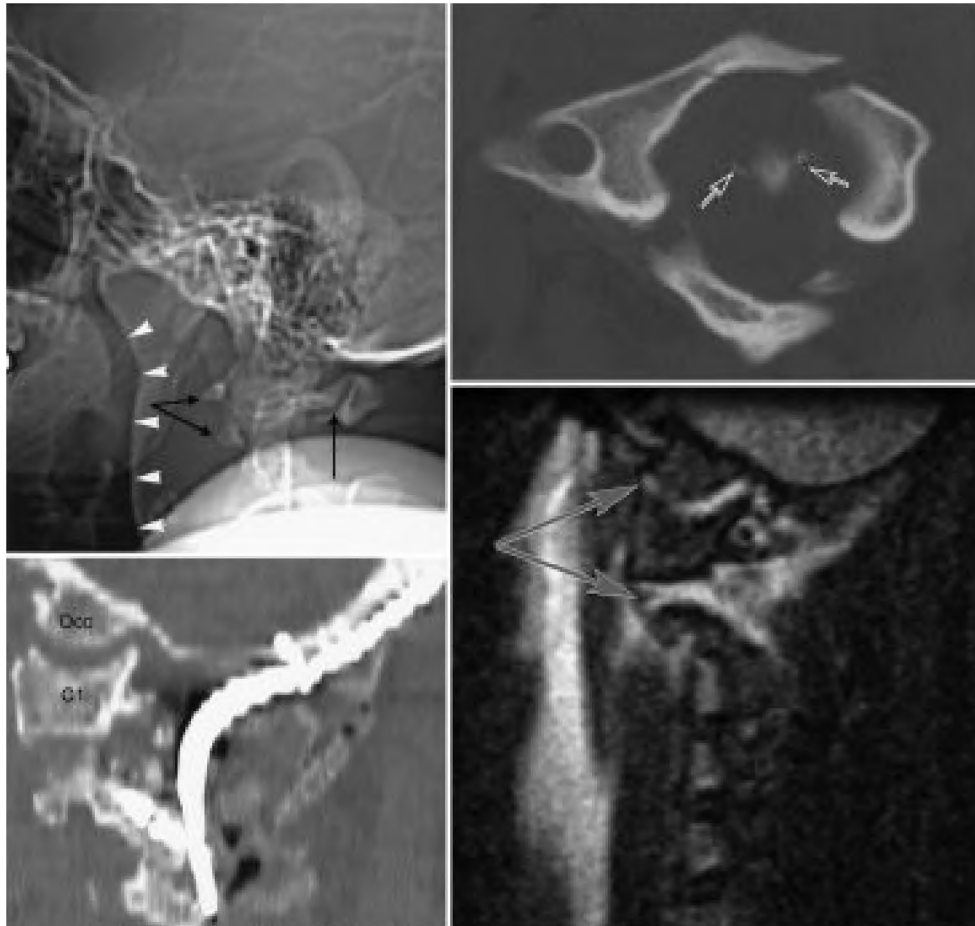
Case 3. Imaging studies documenting neurological decline attendant on a delayed diagnosis: lateral x-ray study (upper left), axial CT (upper right), sagittal CT reconstruction (lower left), and MR image (lower right) obtained in a patient involved in an MVA who presented with neck pain and primary right arm and leg weakness. The C-1 fracture (black arrows [upper left]) was erroneously identified as a Jefferson-type fracture. Widening of the ADI and the significance of bilateral alar ligament avulsions off the odontoid tip (open arrows [upper right]) were underappreciated. Note the anterior soft-tissue swelling (white arrowheads [upper left]). During transfer to the MR imaging unit for additional evaluation, she suffered cardiorespiratory arrest and lost all but trace movement in her extremities despite cervical collar immobilization. Craniocervical dislocation involving the occipitoatlantal and atlantoaxial articulations was confirmed on MR imaging (gray arrows [lower right]). The patient underwent emergency decompression and stabilization (lower left) and injury status improved to an ASIA Grade D and motor function to a score of 82.
